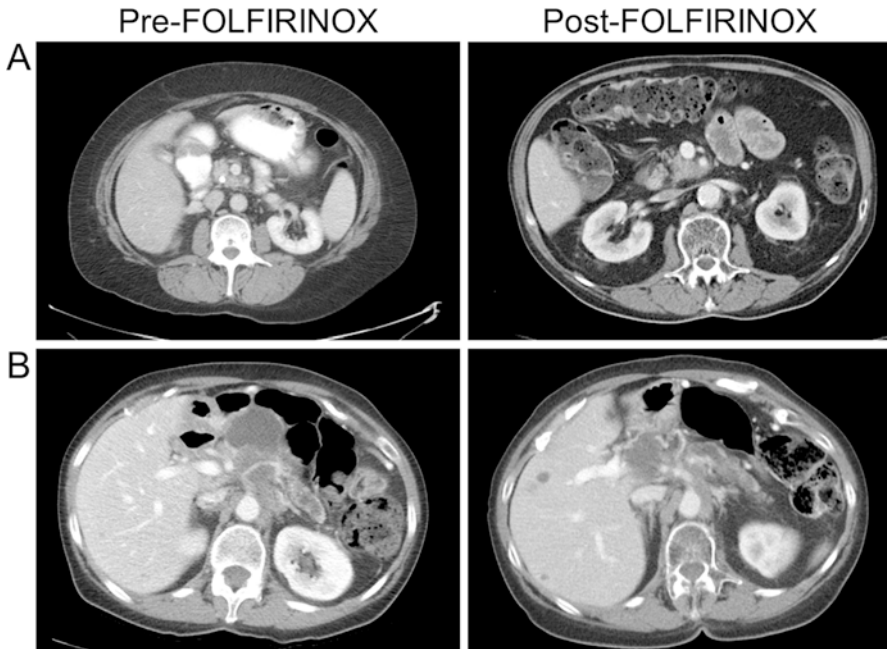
Imaging does not predict resectability after neoadjuvant FOLFIRINOX. (a) 41-year-old female presenting with a 3.6 cm pancreatic mass involving the superior mesenteric artery. CA 19–9 at presentation was 985 U/mL. After 4 months of FOLFIRINOX and 50.4Gy of chemoradiation, her CA 19–9 was 37 U/mL. Final pathology revealed a 1.6 cm T2N0M0 PDAC with negative margins. (b) 69-year-old female presenting with a 4.1 cm pancreatic mass involving of the celiac trunk. CA19–9 at presentation was 13,735 U/mL. After 4 months of FOLFIRINOX and 50.4Gy of chemoradiation, her CA 19–9 was 25 U/mL. The CT scan demonstrated a 1.9 cm pancreatic lesion. Final pathology revealed a 2 cm T2N0M0 PDAC with negative margins
